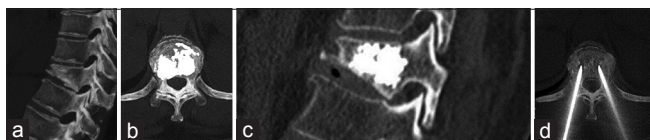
A 67-year-old woman with breast cancer and a solitary D11 vertebral body metastasis. Reformatted computed tomography images before (a) and after treatment (b and c). Coxial percutaneous biopsy and vertebroplasty with bilateral transpedicular access using 13G needles performed in the same session (d)
